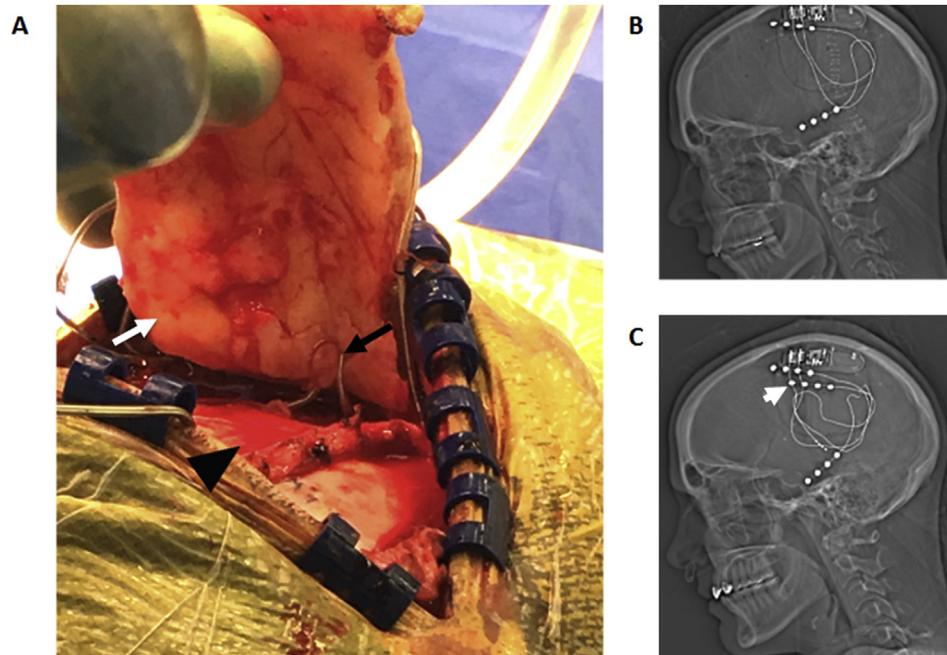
A. Intraoperative photo of the temporal electrode lead encased in bone. The lead was noted to exit the dura (black arrow head) and travel a short distance before becoming encased in bone (black arrow) within the craniotomy flap (white arrow). It then exited the bone and continued to the lead–stimulator junction. B. Scout film from the postoperative CT scan after initial NeuroPace implantation showing the original electrode configuration. C. Scout film from the postoperative CT scan showing the location of the new 4-contact strip electrode (white arrow).
